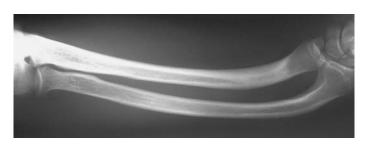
X-ray of radius and ulna in a patient with long-standing chronic renal failure and secondary hyperparathyroidism, showing deformity of the forearm as a result of renal osteodystrophy.
